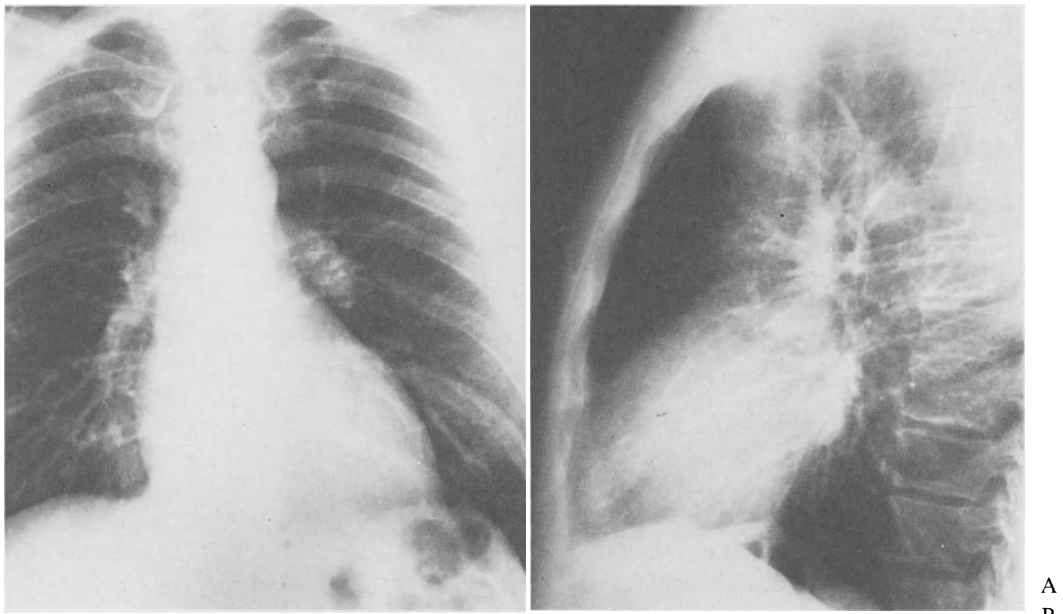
Normal conventional biplane chest X-rays of a 35-year-old male with COCM. (A) Anterior and (B) left lateral positions
